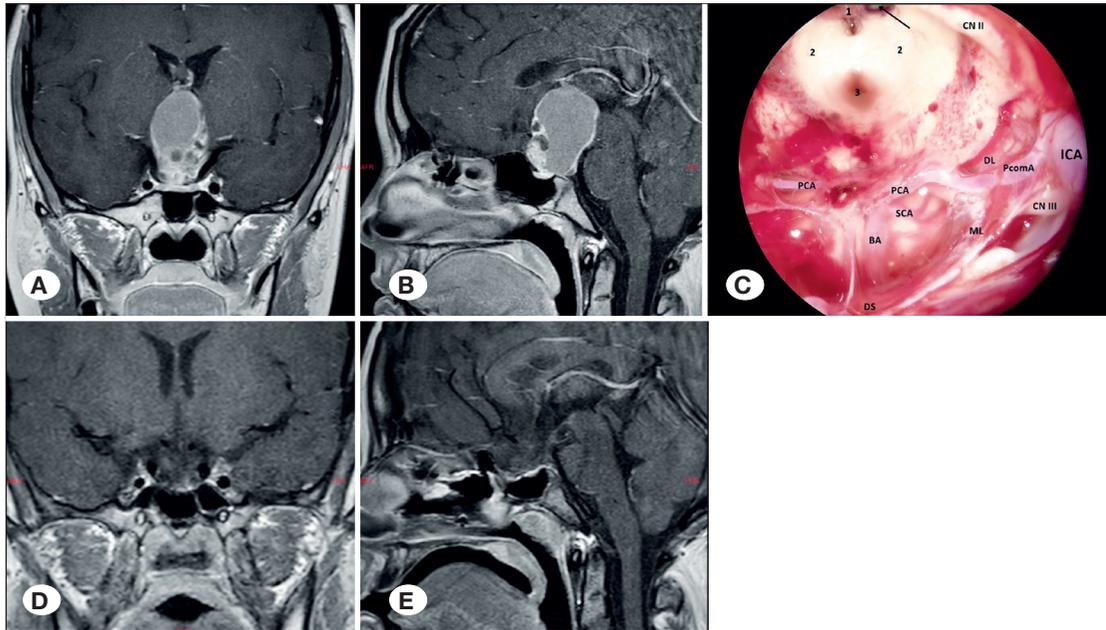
A 13-year-old female with Craniopharyngioma A, B) Preoperative T1-weighted contrast-enhanced coronal and sagittal magnetic resonance imaging (MRI) showing a well-defined solid-cystic mass with mild lobulated contours measuring $34 \times 35 \times 24$ mm. The lesion originates from the posterior clinoid-clivus upper surface, extends posteriorly, and exerts pressure on the interthalamic region, demonstrating peripheral contrast enhancement. C) Intraoperative view after total resection of the mass using an endoscopic transnasal transsphenoidal approach. Key structures are labeled, including ICA (left internal carotid artery - supraclinoid), PcomA (left posterior communicating artery), PCA (posterior cerebral artery), SCA (left superior cerebellar artery), BA (basilar artery), CN (cranial nerve), DS (diaphragma sella), ML (mesencephalic leaf), DL (diaphragmatic leaf), (1) choroid plexus, (2) thalamus, (3) cerebral aqueduct, and (arrow) left foramen of Monro. D, E) Postoperative second year, T1-weighted contrast-enhanced coronal and sagittal MRI, showing total removal of the mass without recurrence.
